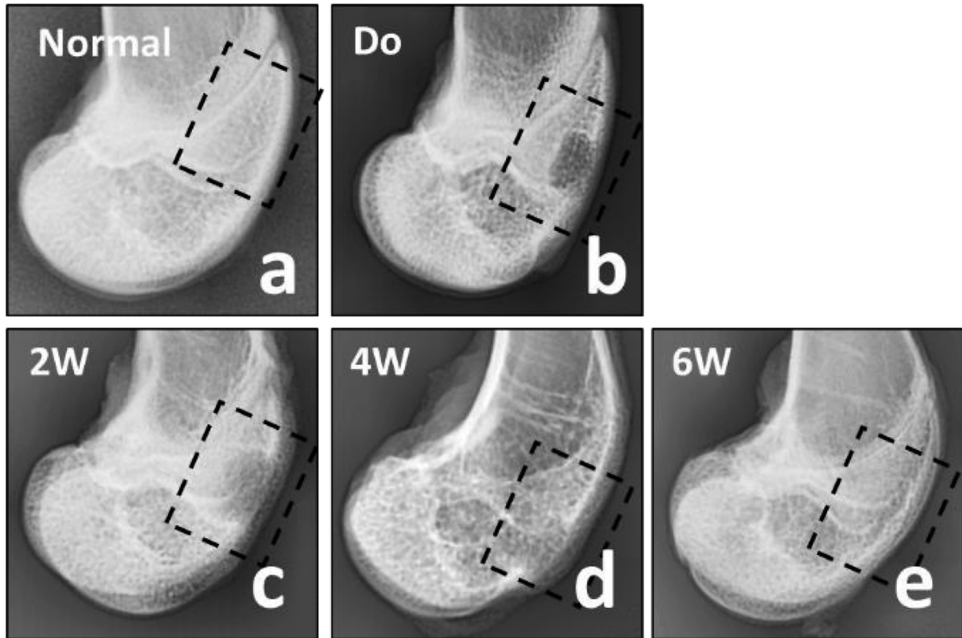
Assessment of subchondral bone formation by radiography
